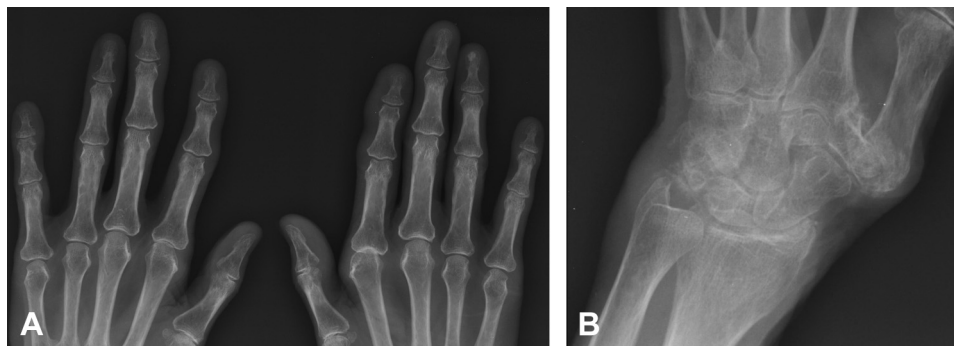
Radiograph of the hands. A, Soft tissue swelling along with periarticular calcifications at both 1st carpometacarpal joints. There is no digital calcification. B, Calcification in the region of the triangular cartilage on the left and adjacent to the triquetrum and ulnar styloid process of the left hand.
